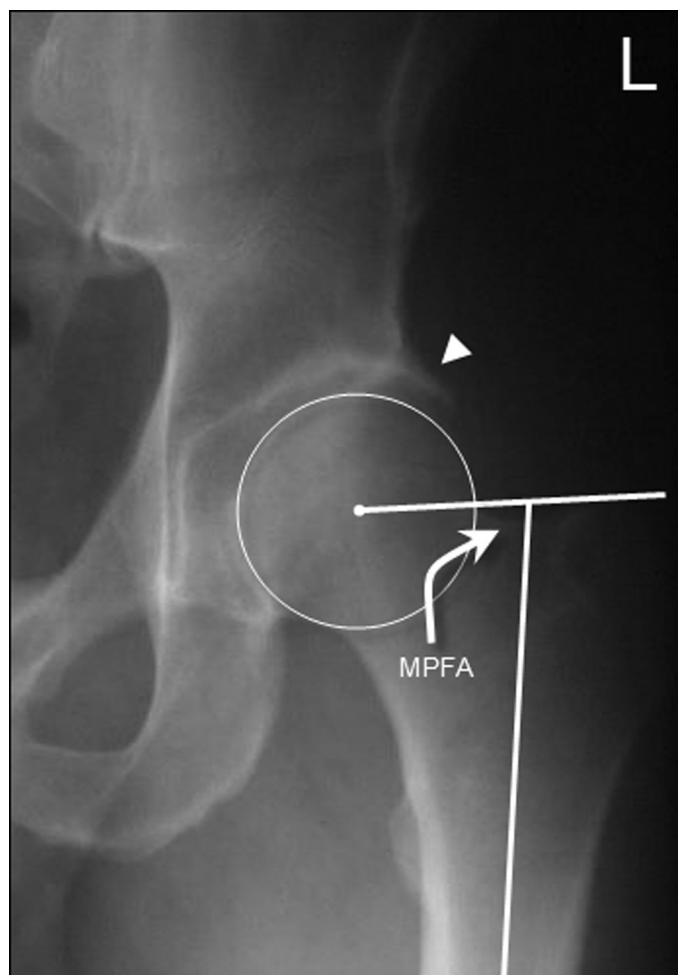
Medial proximal femoral angle (MPFA). AP radiograph of the left hip joint (in a 36-year-old male patient) showing the modified MPFA. A line is drawn from the superior tip of the greater trochanter through to the centre of the femoral head. A second line is drawn (representing the anatomical axis of the proximal femur) from the midpoint of the most distally visible aspect of the femoral shaft, and up proximally through the piriformis fossa. The medial angle formed by these two lines is the MPFA (normal range = 80° to 89°). Note the ossification of the lateral acetabular labrum (arrowhead), resulting in pincer FAI.
